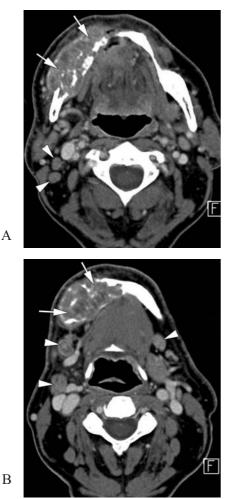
A-B. Axial CT-images in a patient suffering large squamous cell cancer originating from right mandibular gingiva. Large, heterogeneously enhancing soft tissue mass, invading the mandibular bone is evident (arrows). Several rounded, slightly enlarged
